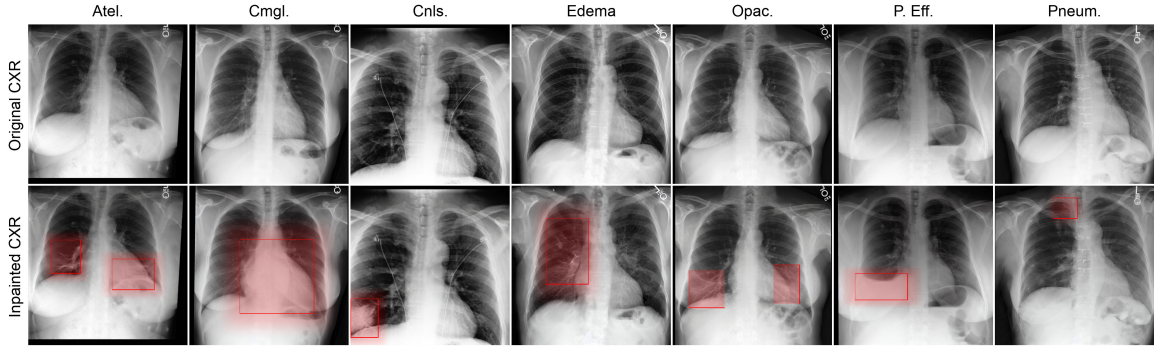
Examples of *SemiSynCXR*-generated CXRs. We show the real, healthy chest X-rays (top) and edited versions (bottom). The red outlines correspond to the conditioning masks alongside their non-blurred version, which serve as training targets (bounding boxes) for localization models.
